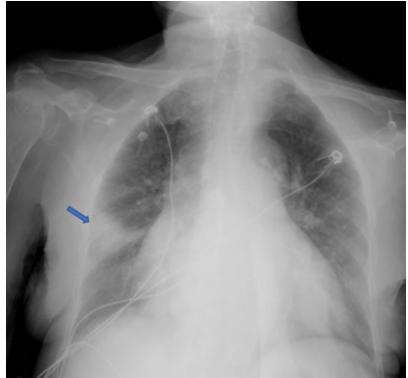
Chest radiograph showing a wedge-shaped area of opacity consistent with a Hampton Hump on the right side (arrow).
